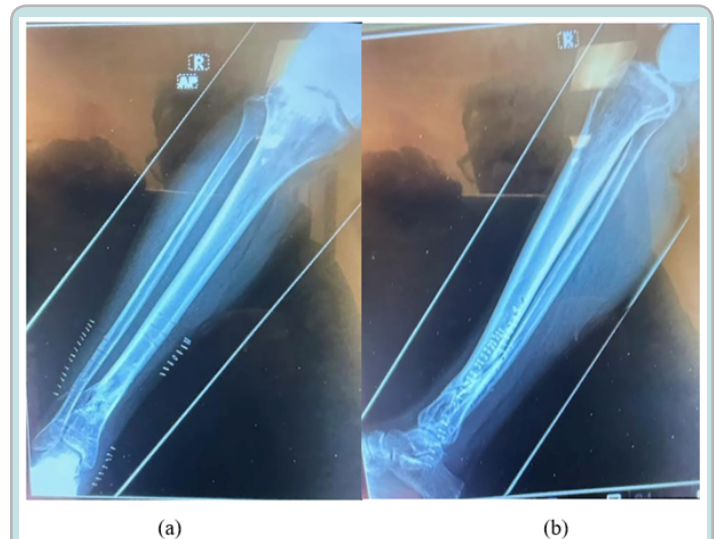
X-rays (a,b) captured after 6 weeks of fESWT.
